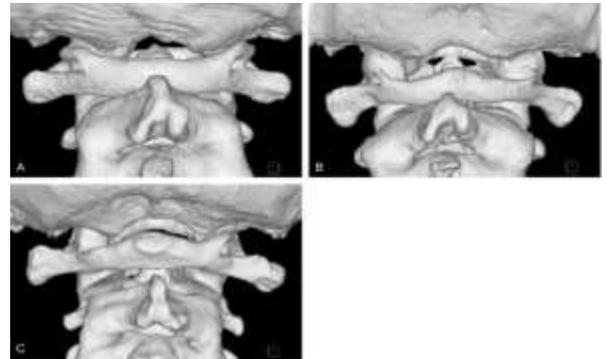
Various types of ponticuli posticus seen on three-dimensional CT images. (A) Bilateral complete. (B) Complete on the left side and partial on the right side. (C) Unilateral
